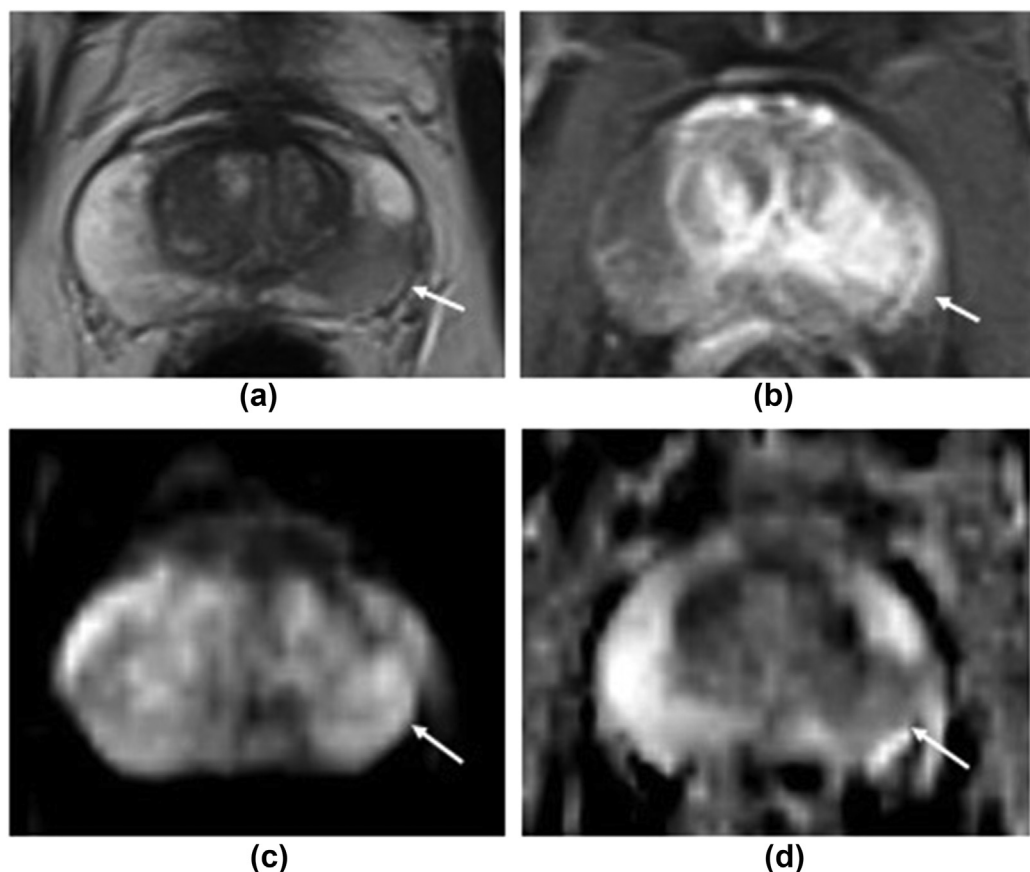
A 65-year-old man with a history of metastatic colorectal adenocarcinoma. MRI pelvis as part of surveillance imaging demonstrated prostatomegaly with a new 1.5 cm T2 hypointense focus in the left posterolateral peripheral zone (a, arrow) with abnormal enhancement (b, arrow), restricted diffusion (c, arrow) and signal loss on ADC maps (d, arrow). This patient was treated for prostatitis and follow-up imaging confirmed interval resolution of signal abnormalities in the prostate gland.
